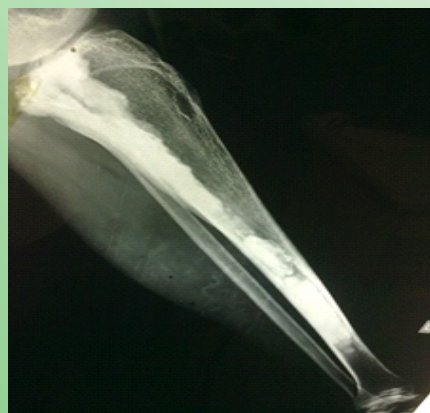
Full Length Leg Bone Lateral View X-ray.
